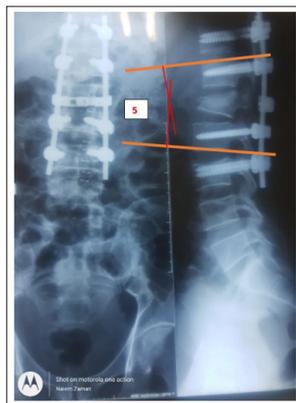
postoperative x-ray. After PSO, the kyphosis angle was found to be only 5 degrees
